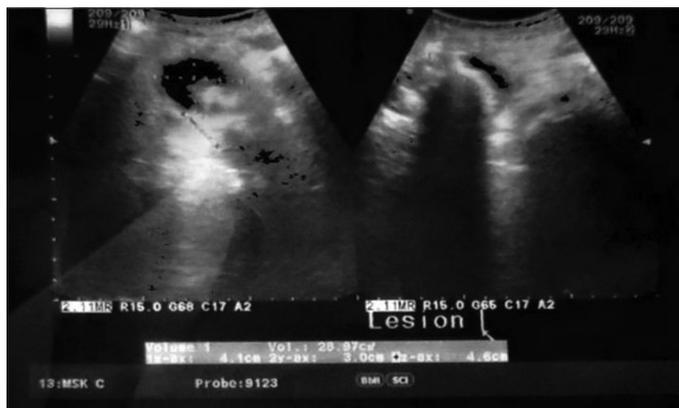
Ultrasound suggestive of localized sealed bowel perforation/diverticular perforation with adjacent loculated collection
